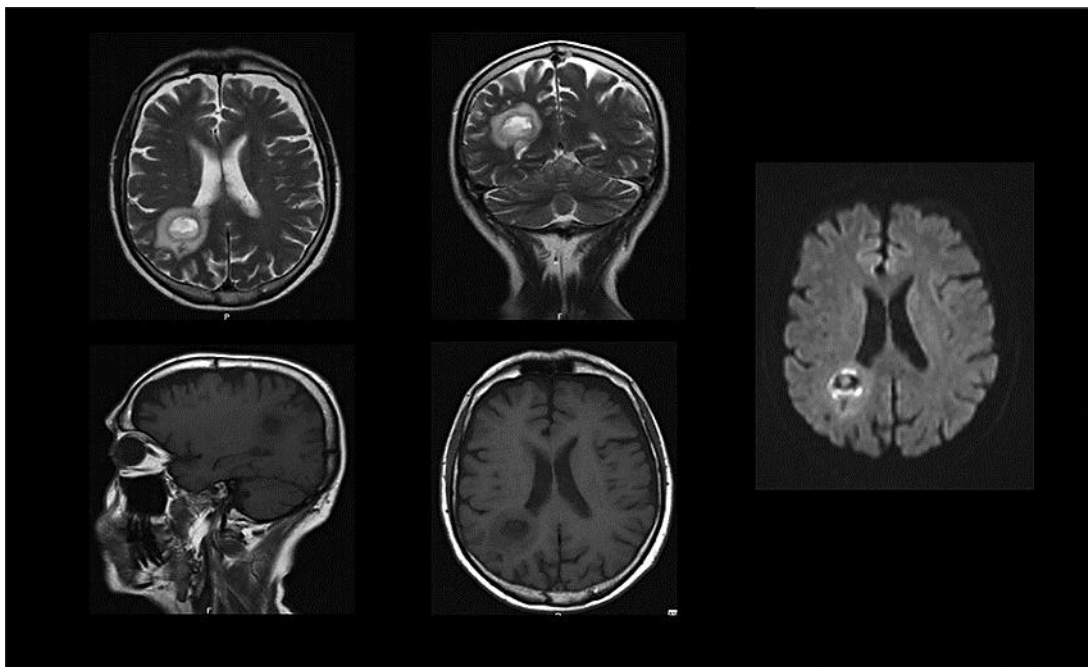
MRI of the brain showing worsening of the right frontoparietal lesion after 4 weeks of treatment with ceftriaxone combined with metronidazole. On T2-weighted images, the central abscess is hyperintense, with a hypointense surrounding capsule and extensive surrounding edema.
